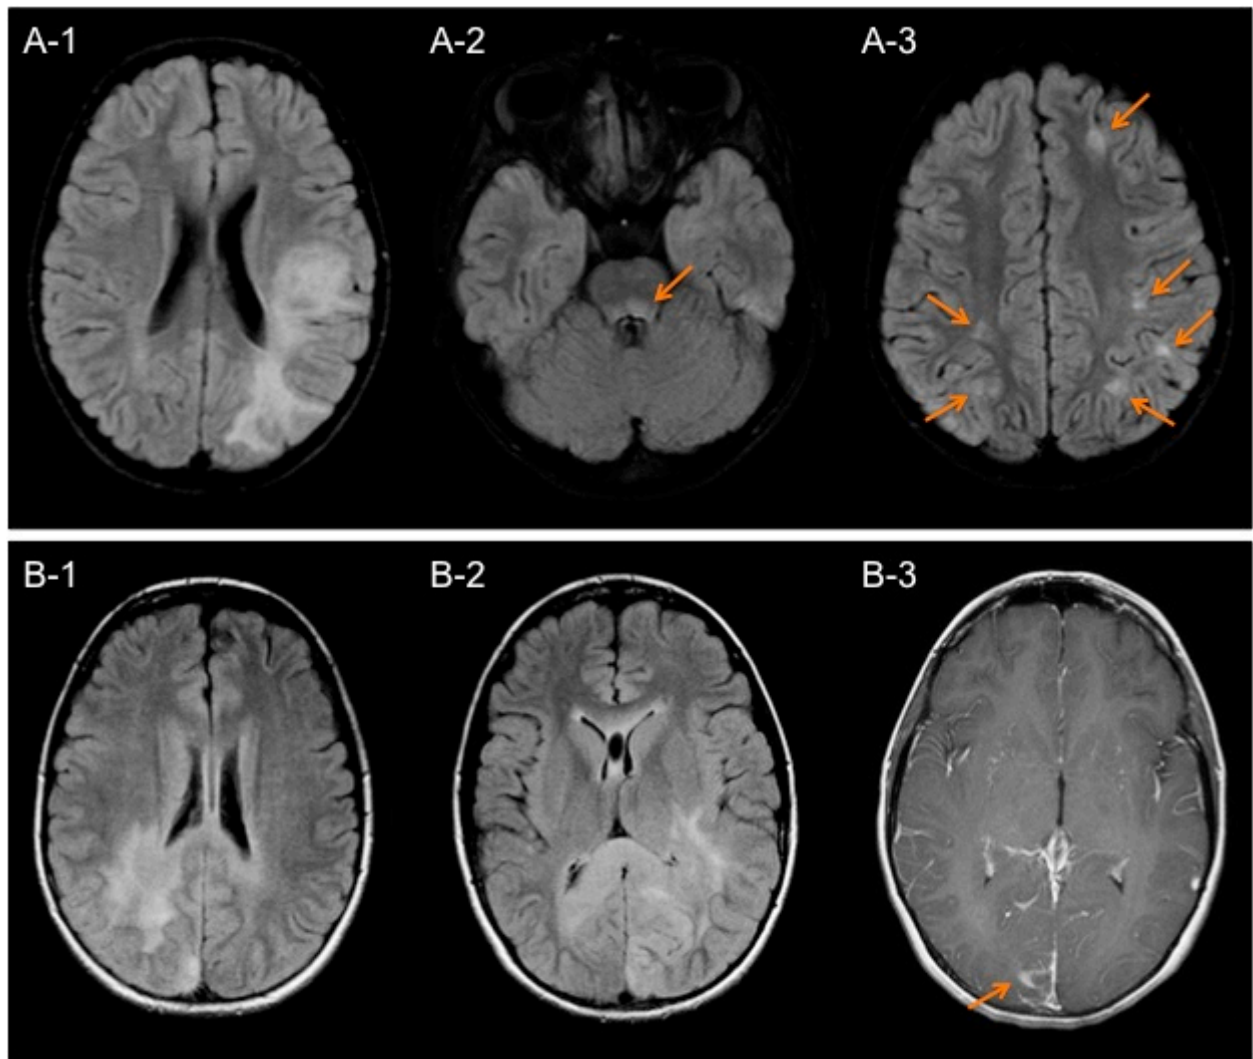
MRI features of tumefactive demyelination compared with tumor. (A-1) Axial FLAIR imaging acquired at the time of first attack reveals a tumefactive demyelinating lesion involving the posterior hemispheric white matter in a child with MS; post-contrast T1-weighted imaging was not acquired at the time of onset. (A-2, A-3) Axial FLAIR images acquired 15 months after baseline MRI (A-1) showing new brainstem, juxtacortical and cerebral white matter lesions (arrows). (B-1, B-2) Axial FLAIR imaging shows a tumor involving the cortex, posterior hemispheric white matter and splenium of the corpus callosum in a child initially evaluated for
